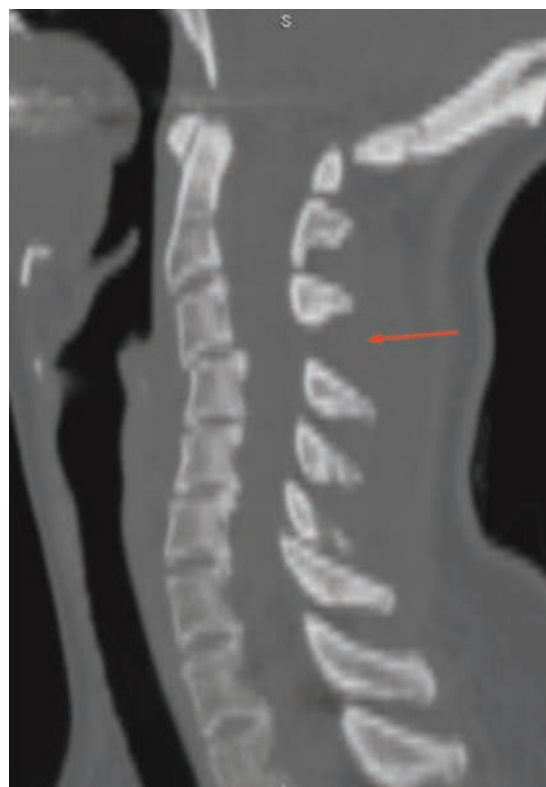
Sagittal computed tomography reformat on bony windows showing malalignment of the cervical spine and splaying of the spinous processes (arrow), with anterior displacement of the C3 vertebra relative to C4
